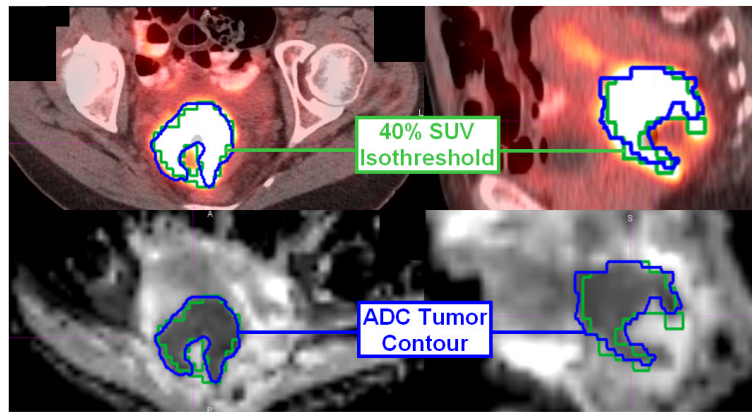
FDG-PET/CT (top) and DWI (bottom) axial (left) and sagittal (right) images fused for one sample patient. The 40% SUV isothreshold is outlined in green, and the tumor volume delineated on the ADC map is outlined in blue.
